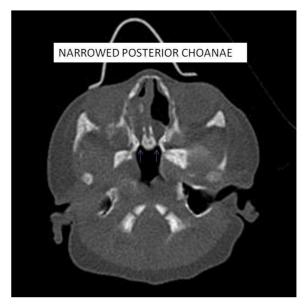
Axial CT section showing medial bowing and thickening of posterior- medial maxilla
